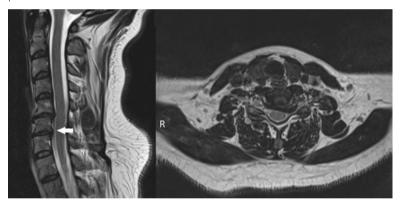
Sagital and axial magnetic resonance imaging of the bulging disc at level C6–C7 left.
